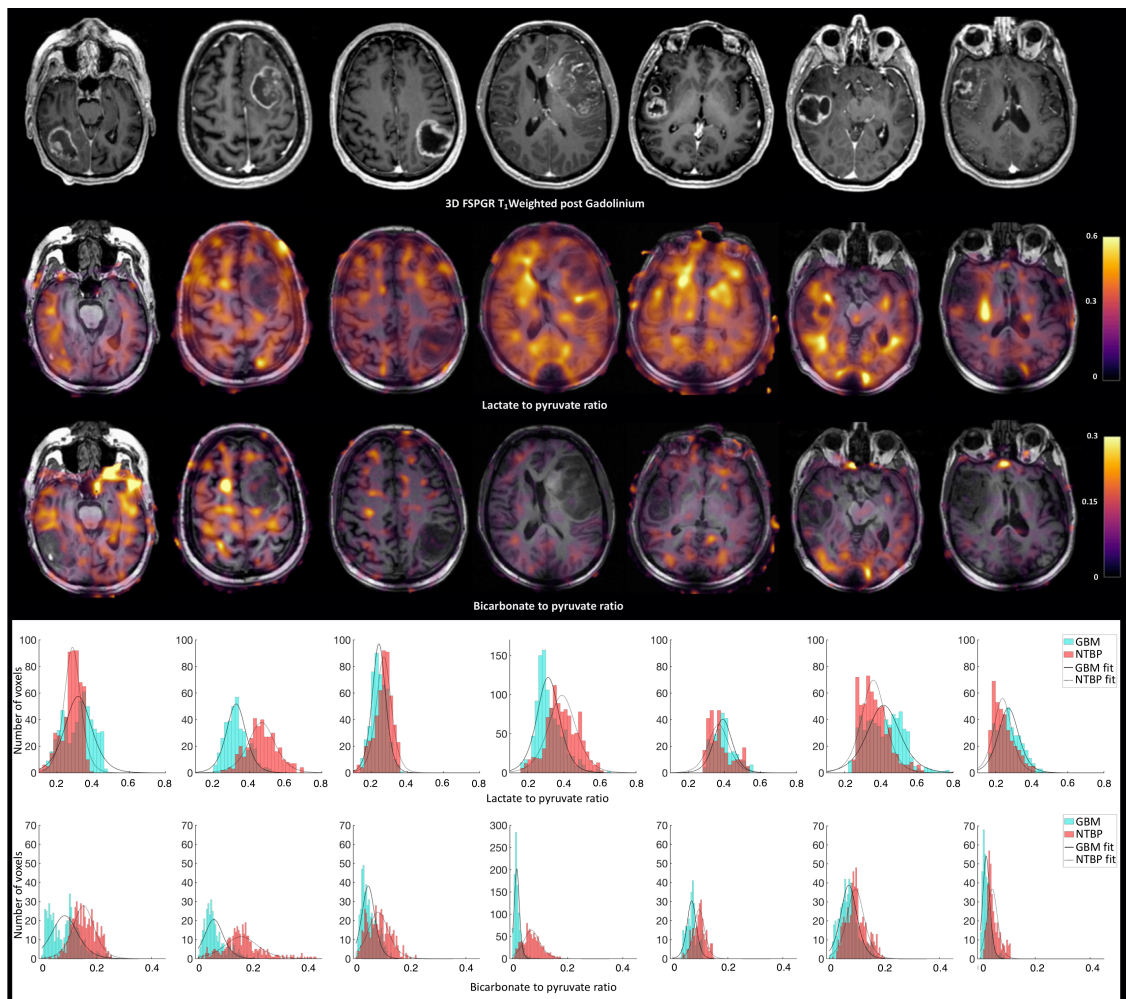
Hyperpolarised ^{13}C MRI of the entire cohort.
